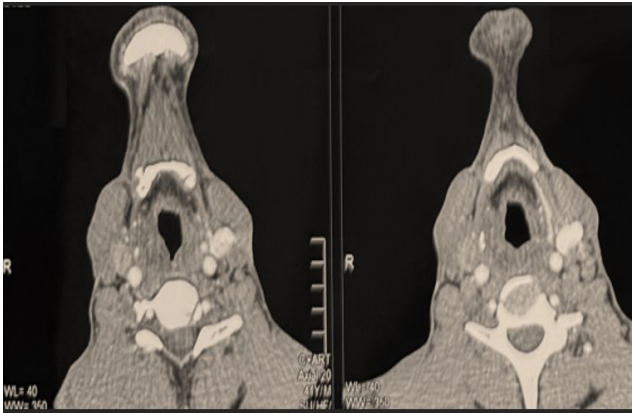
Cervical CT scan showing edematous thickening of the supraglottic region of the larynx.
